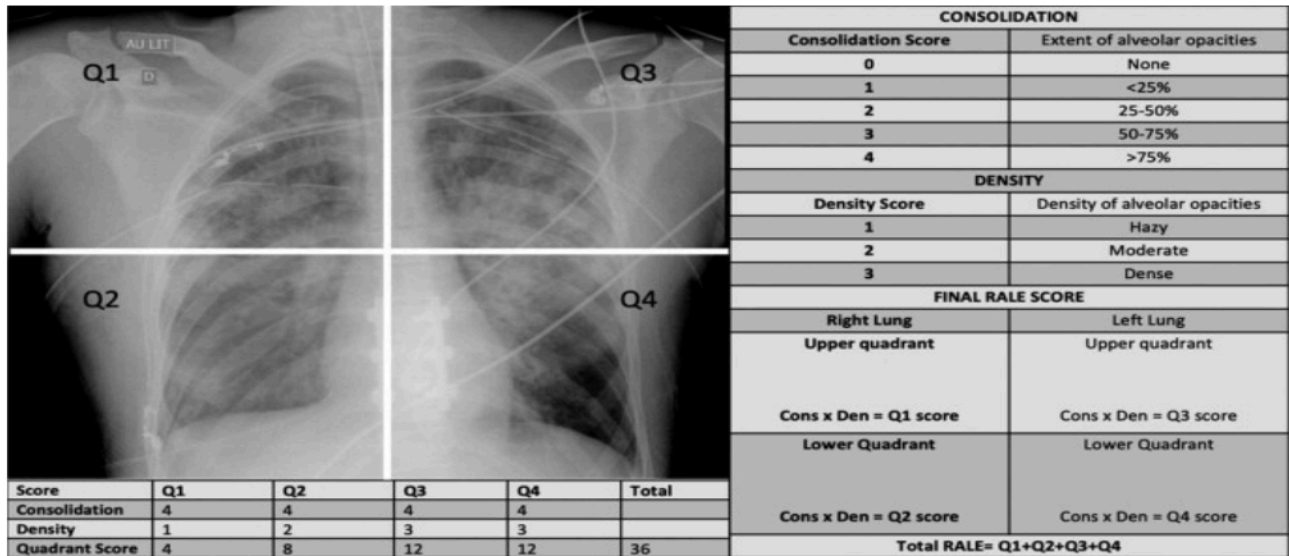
Consolidation and density scoring in the RALE score (Panel A), Calculation of the Radiographic Assessment of Lung Edema (RALE) score (Panel B)
